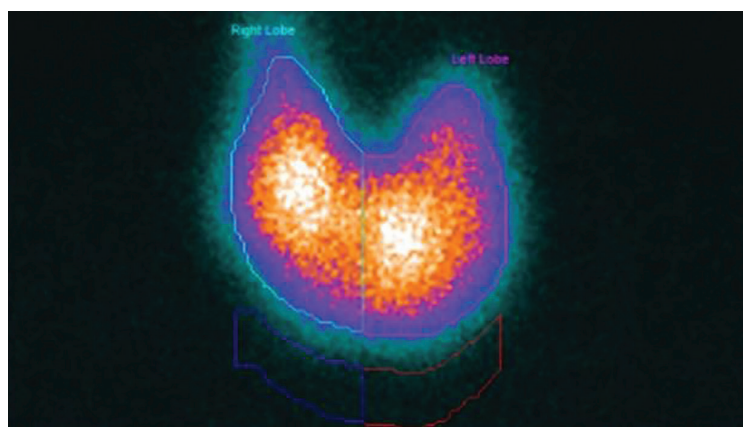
Radionuclide Tc99m thyroid scintigraphy showing bilateral diffuse homogenous tracer uptake 20.4%, (normal 5-15%), suggesting hyperfunctioning thyroid gland in Graves' disease.
